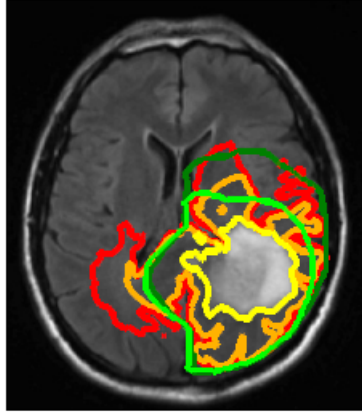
Comparison of manually defined targets (light/dark green) and model based targets (red/yellow). Light green contour represents boundary of T2-FLAIR with isotropic margin while dark green is PTV [18].
